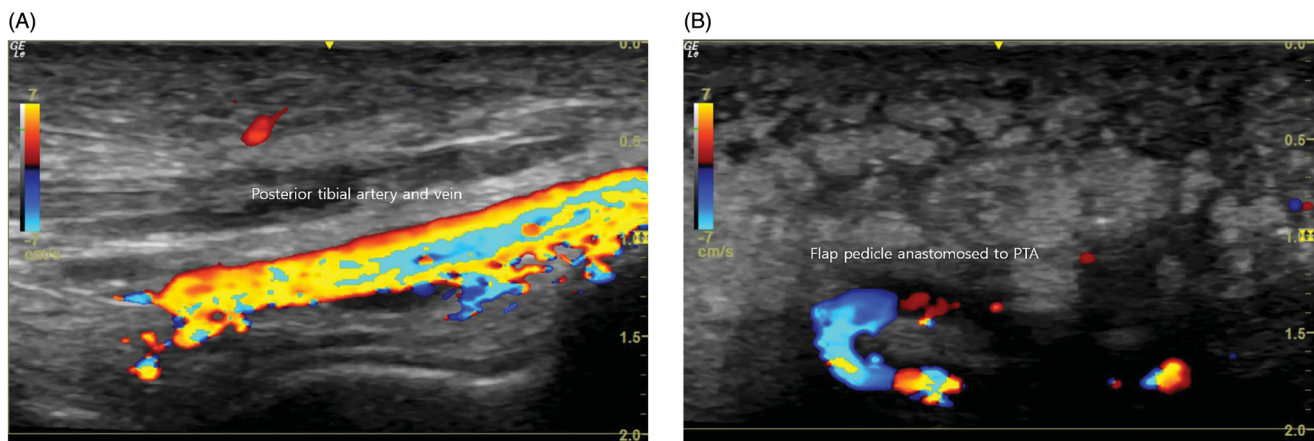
Flap circulation monitoring by color Doppler sonography (Patient no. 8). (A) Color Doppler flow image of the posterior tibial vessel. (B) Color Doppler flow image of the flap pedicle. The posterior tibial vessel and flap pedicle were easily identifiable. Arterial and venous blood flow of the supraclavicular VLNT was confirmed by Color flow duplex imaging. VLNT was deemed surviving functionally at 6 months after surgery.
